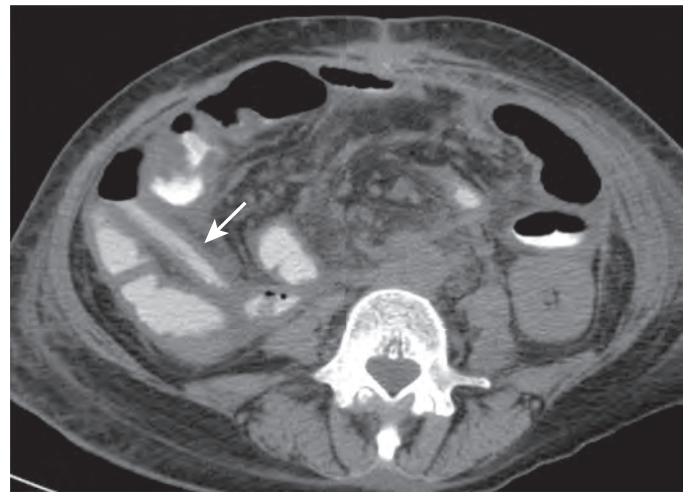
Small bowel transplant rejection. Unenhanced CT image in a 60-year-old woman with a history of small bowel transplantation. Small bowel loops within the right lower quadrant showing loss of bowel fold pattern and diffuse thickening (arrow). There is also mesenteric edema and a small amount of free fluid. The patient had a small bowel biopsy, and acute rejection was diagnosed.
